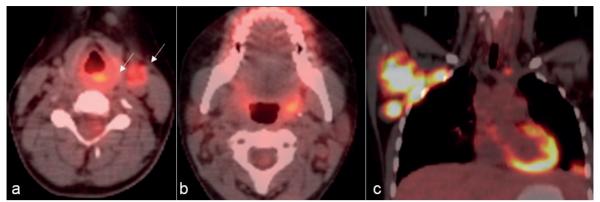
Positron emission tomography - computed tomography of Case 2 shows increased fluorodeoxyglucose (FDG) uptake in the posterior part of the left ventricular band and the lymph node at level 3 (arrows in image a). Increased FDG uptake can also be seen in the left palatine tonsil (b), the right axillary, mediastinal lymph nodes, and the left pulmonary nodule (c).
